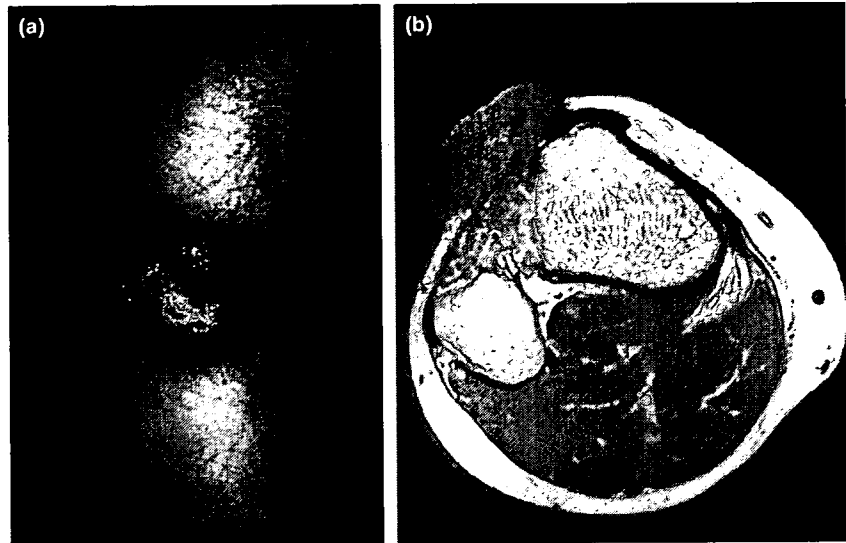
(a) Brown, firm nodule, 50 mm in diameter, immobile owing to adhesion to the subcutaneous tissue; (b) magnetic resonance imaging demonstrated invasion close to the fascia of the anterior tibial muscle.
